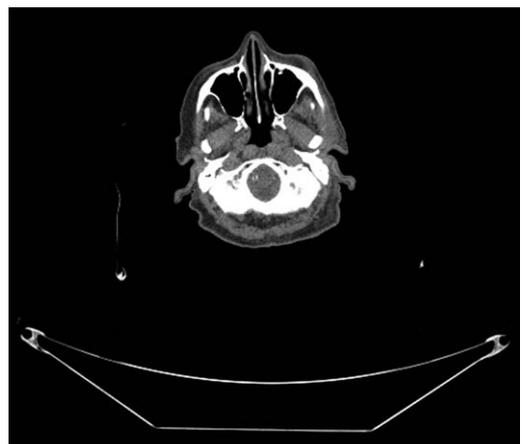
CT scan obtained 12 months after the completion of radiotherapy showing resolution of disease.
